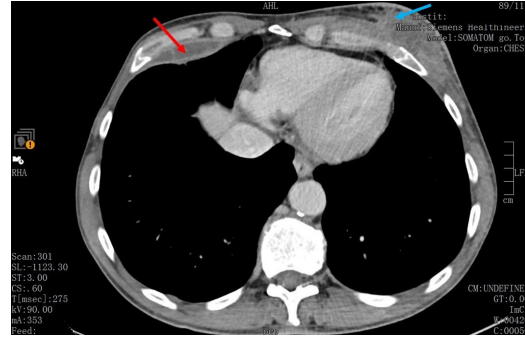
CT scan revealing an abscess on the right cardiophrenic recess of 50 x 13 mm (red arrow) and also showing a lateral left thoracic wall abscess of 49 x 20mm (blue arrow).
